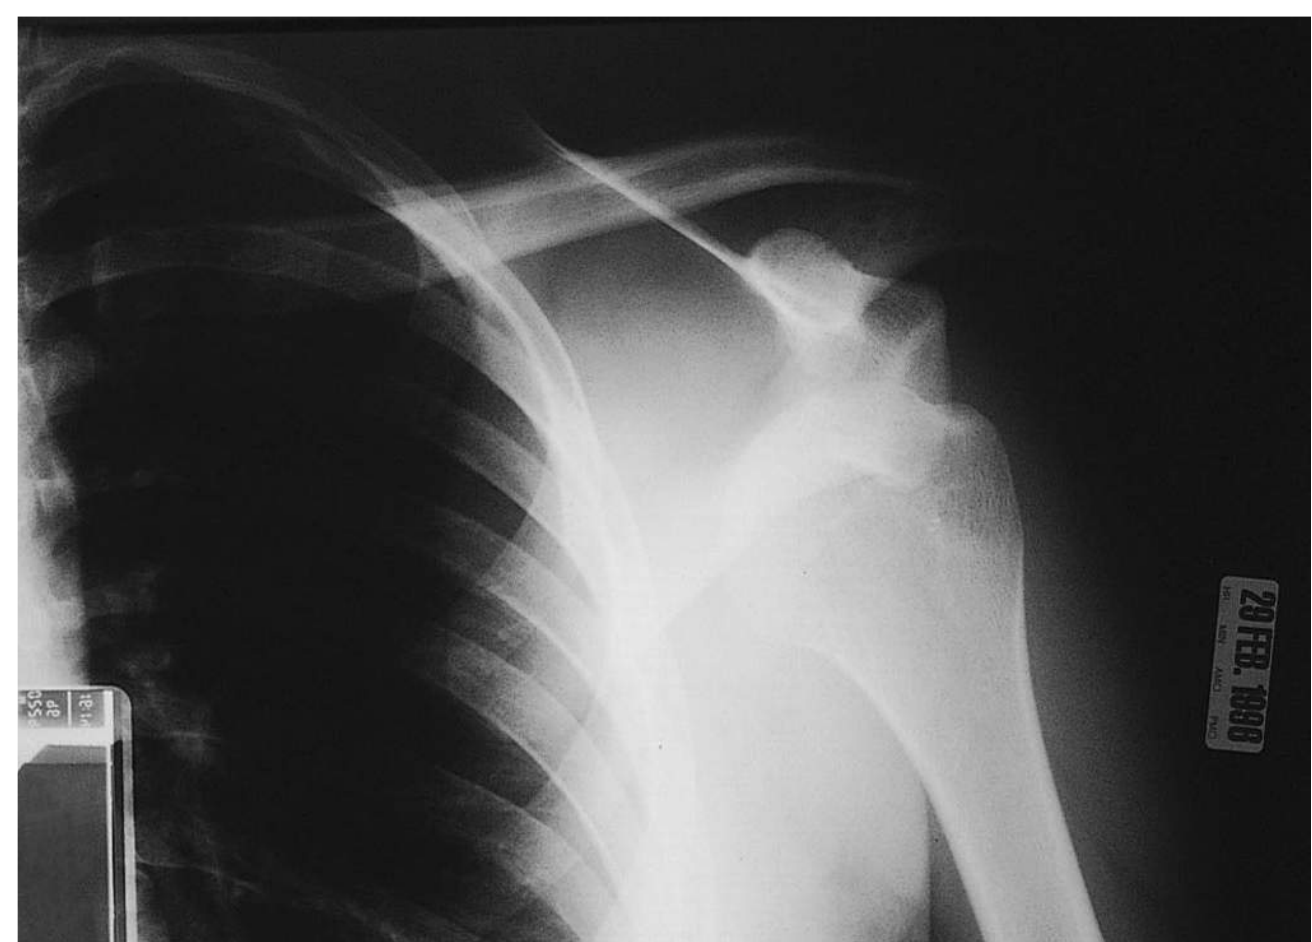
■ Anterior Shoulder Dislocation. Radiographic evaluation demonstrates that the humeral head is not in the glenoid fossa but is located anterior and inferior to it. (Photo contributor: Kevin J. Knoop, MD, MS.)
